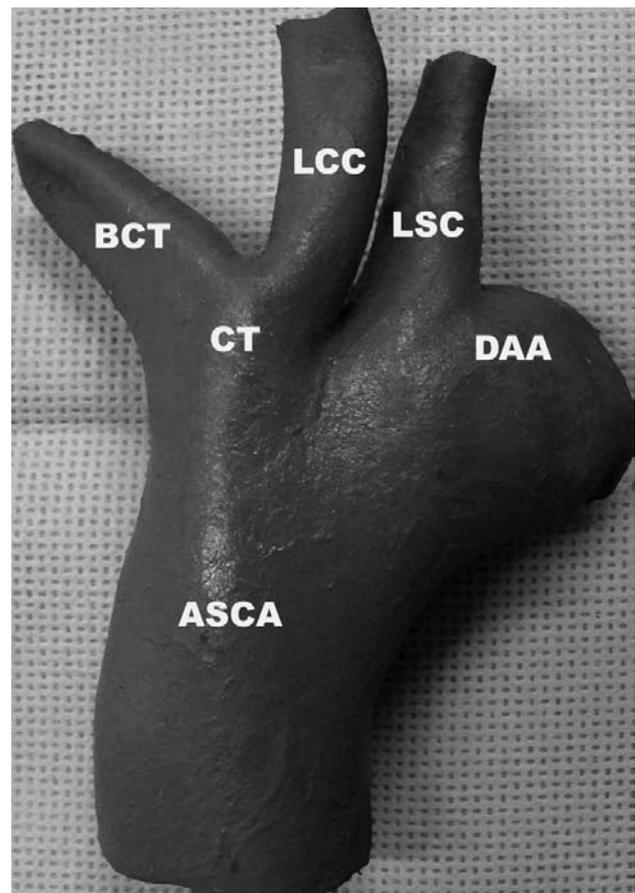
Previous view of the aortic arch and its branches. Presence of the common trunk (CT), brachiocephalic trunk (BCT), the left common carotid artery (LCC), left subclavian (LSC), ascending aorta (ASCA), Distal aortic arch (DAA)
